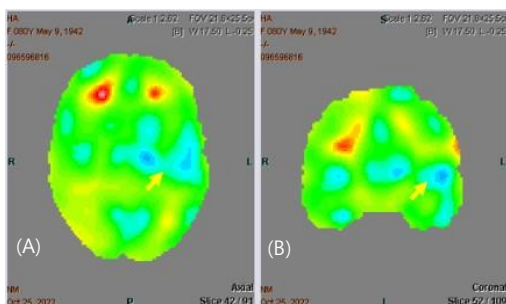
Transverse view (A) and coronal view (B) of single-photon emission computed tomography image on October 28, 2022, which show a mild decrease in perfusion in the left temporal lobe.
